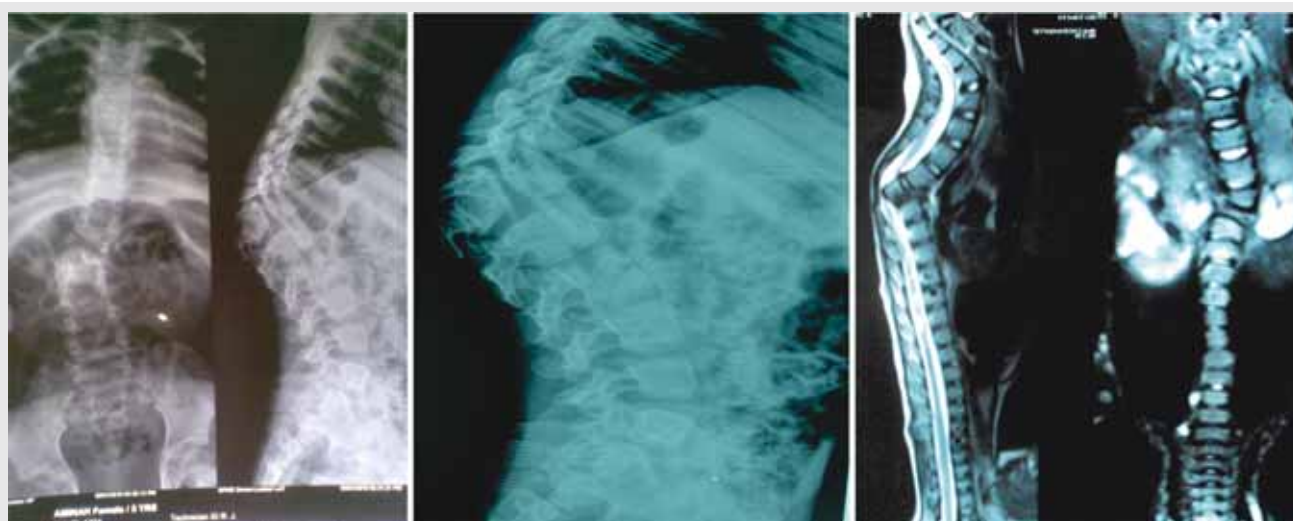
Congenital Angular Kyphosis in a 4 year old child. There is defect of formation anteriorly. It has lead to only formation of posterior elements and classical Y shaped disc is seen anteriorly on xray and MRI image. At the age of 4 years there is 100 degree of angular kyphosis. These patients should not wait till maturity and should be operated at the earliest.
